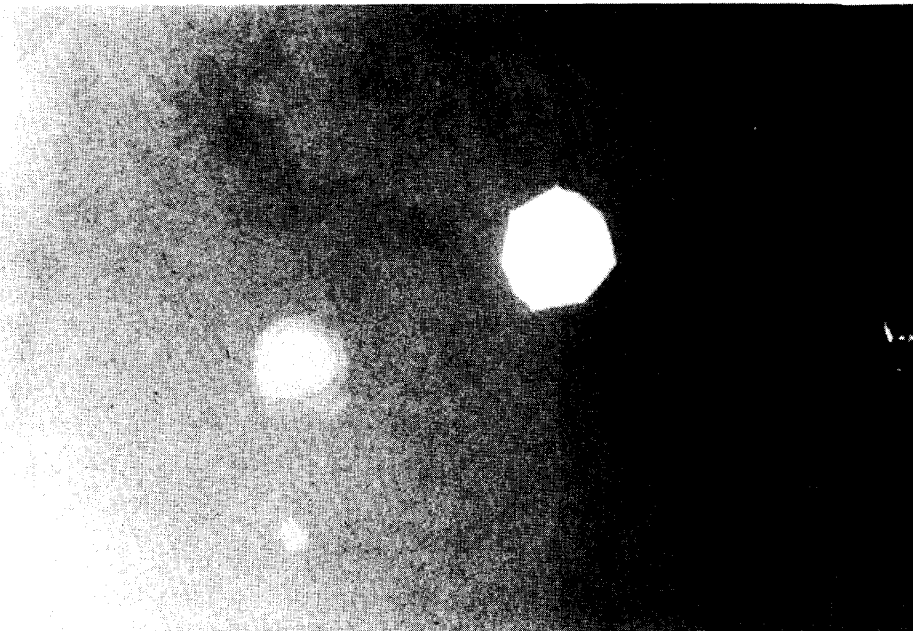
X-ray film of phlebolithiasis.
